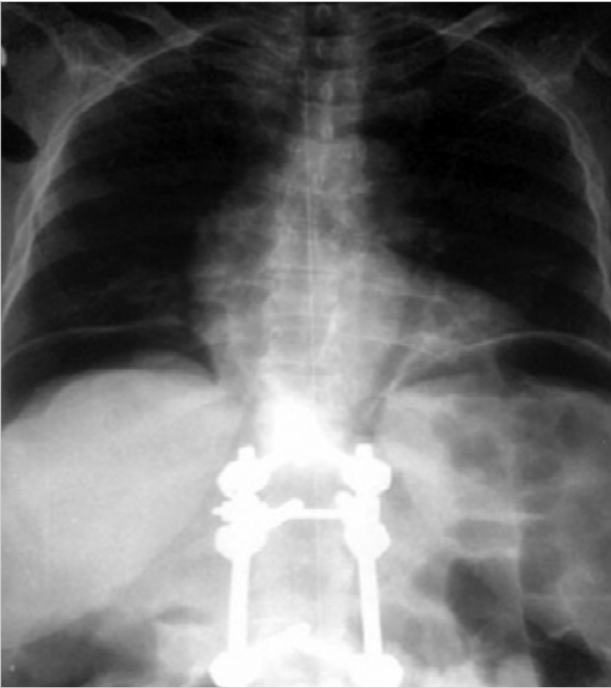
Subdiaphragmatic free intraabdominal air in a patient's upright abdominal X-ray 5 days after stenting of a tumoral obstruction in the rectosigmoidal region who underwent emergent surgery due to colon perforation
